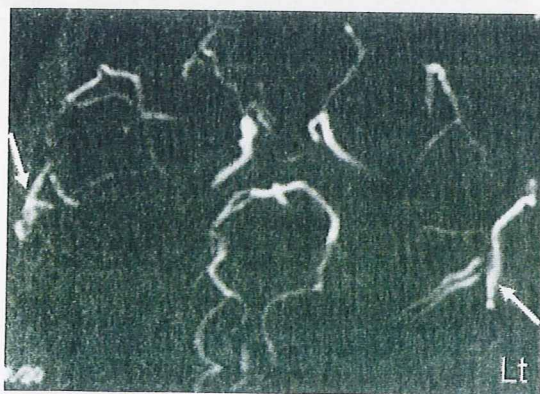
Preoperative cerebral angiography showed stenosis of bilateral internal carotid arteries, middle cerebral arteries and anterior cerebral arteries. Basal moyamoya vessels were developed obviously on the left and slightly on the right (A). Preoperative  $^{123}\text{I}$ -IMP-SPECT showing mildly decreased cerebral blood flow (B) and severely compromised reserve capacity of bilateral cerebral hemispheres (C).
